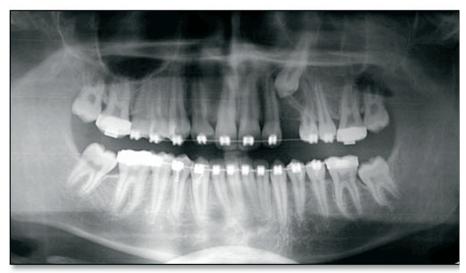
Panoramic radiograph at age 16 years 1 month.
